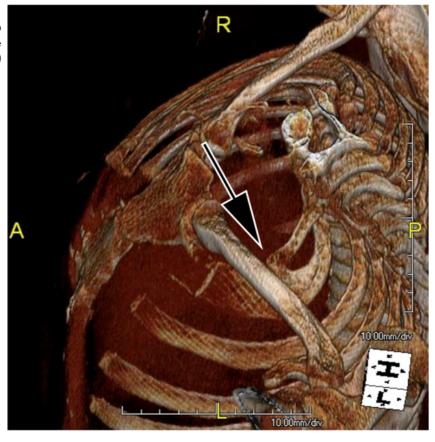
From Hidlay, T. 2014. Superior lateral view,3D CT reconstruction demonstrating rib anomaly in close proximity to the clavicle (black arrow)
